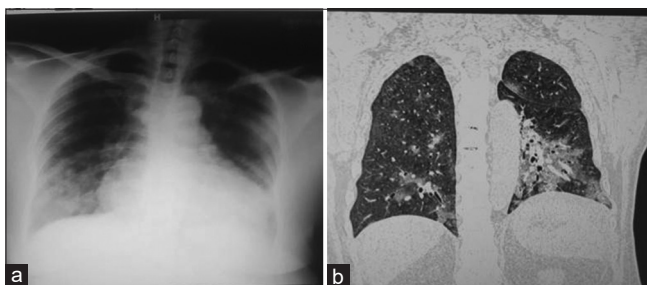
(a) Chest X-ray AP (anterior-posterior) view of Patient 2 showing right lower zone consolidation and changes of fluid overload. (b) HRCT (high-resolution computed tomography) chest of Patient 4 showing bilateral ground-glass opacities correlating with CORADS 6
